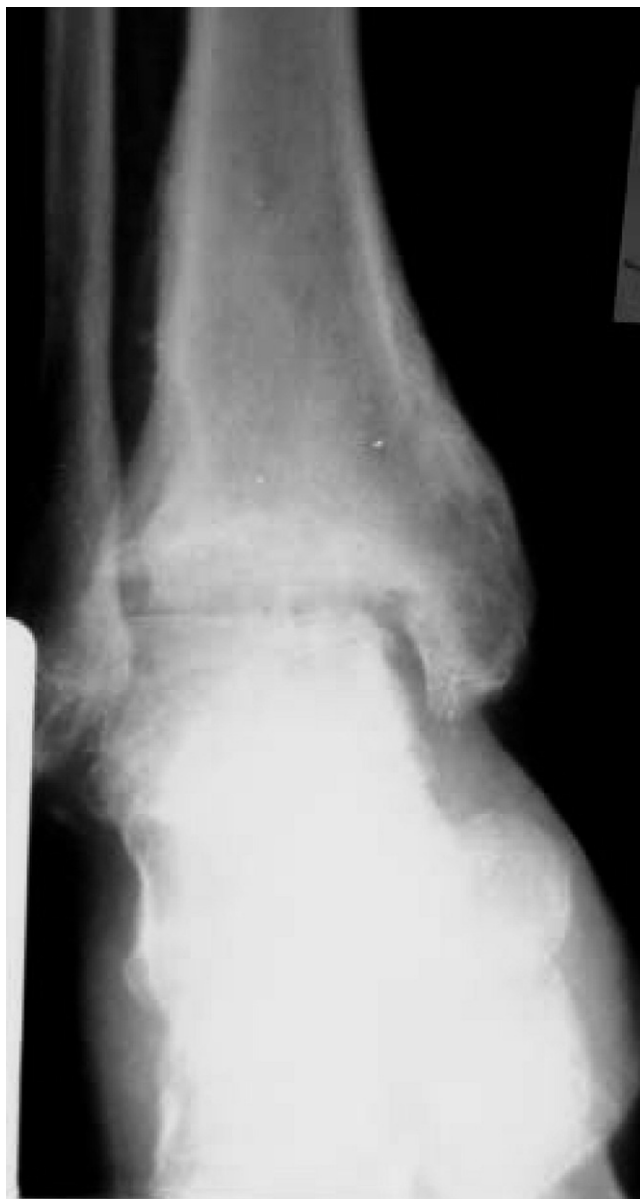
Typical pre-operative ankle anterior-posterior weight-bearing x-ray.
